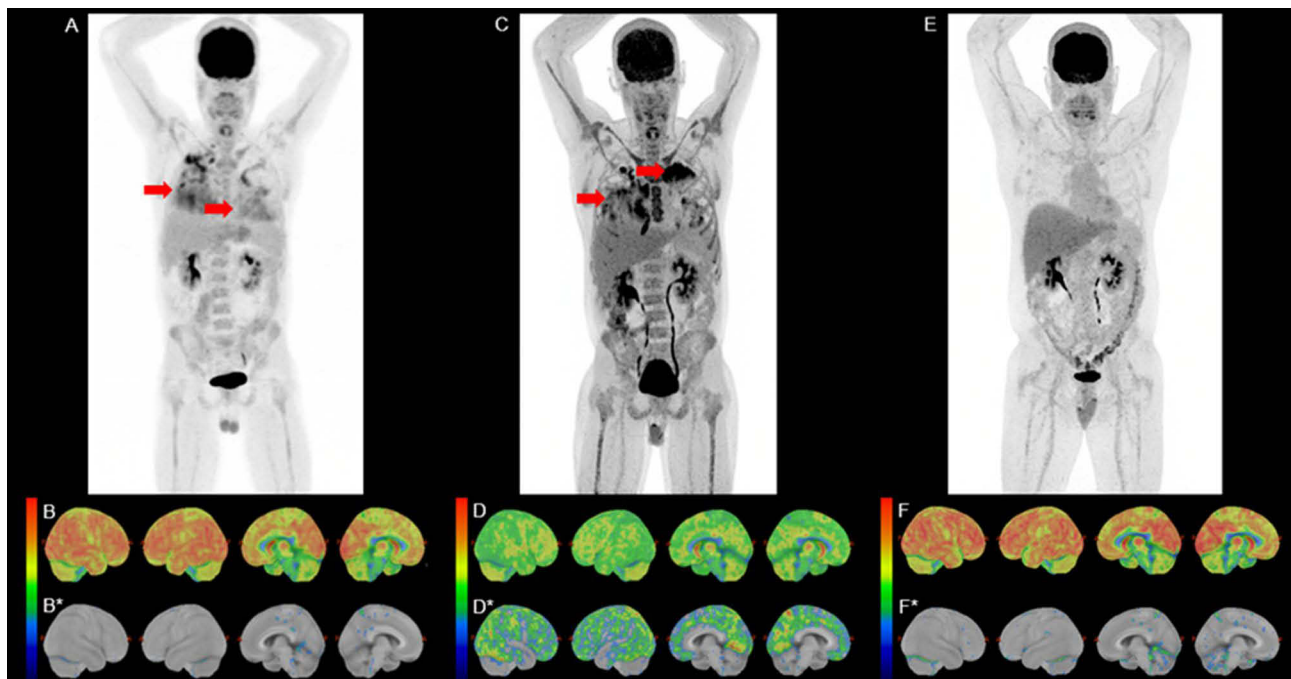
Reversible global cerebral hypometabolism on serial 18F-FDG PET. Whole body maximum intensity projection (MIP) and 3-D surface rendering of brain 18F-FDG uptake of man with refractory transformed follicular lymphoma and reversible cerebral glucose hypometabolism. At time of initial 18F-FDG PET imaging shown, the patient was noted to be in complete remission approximately one year after CAR-T and systemic targeted therapy but had developed COVID-19 pneumonia as shown on the 18F-FDG MIP (red arrows) (A). 3-D 18F-FDG PET brain metabolism surface rendering using dedicated imaging software (GE AW server 3.2 with Cortex ID, MIM Neuro, version 7.2.7) shows relatively normal visual global metabolism (B) and no focal or global hypometabolism when compared to age and gender matched normal cohort in the database (B*). Three months later, the patient presented with confusion and impaired memory in conjunction with worsening COVID-19 associated cryptogenic organizing pneumonia (COP) as seen on whole body imaging (red arrows) and no evidence of recurrent lymphoma (C). 3-D 18F-FDG PET brain surface rendering at that time demonstrated visual evidence of severe global cerebral hypometabolism (D) and statistical hypometabolism when compared to aged-normalized controls (D*). Subsequently, patient was started on prednisone with rapid reversal of his neurocognitive symptoms and subsequent 18F-FDG PET demonstrated resolution of pulmonary inflammation (E) and return to baseline normal brain metabolism (F) and aged-normalized control comparison (F*).
